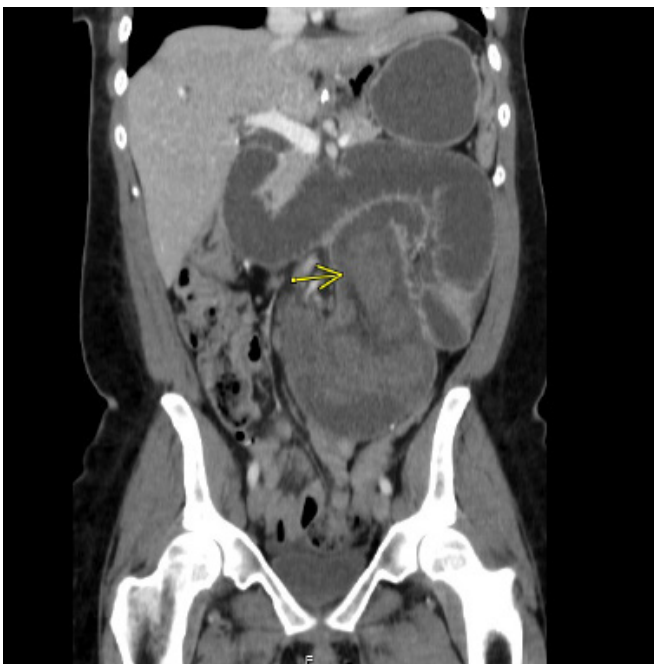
Axial CT Image Demonstrating Intussusception at Second Presentation. Published with Permission
